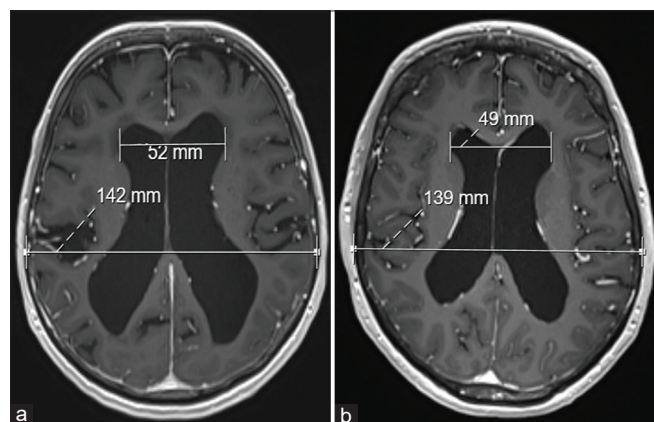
Preoperative axial T1 magnetic resonance imaging demonstrating supratentorial ventriculomegaly in both patients, as indicated by an Evan's index of 0.35 in (a) patient 1 and (b) patient 2.
